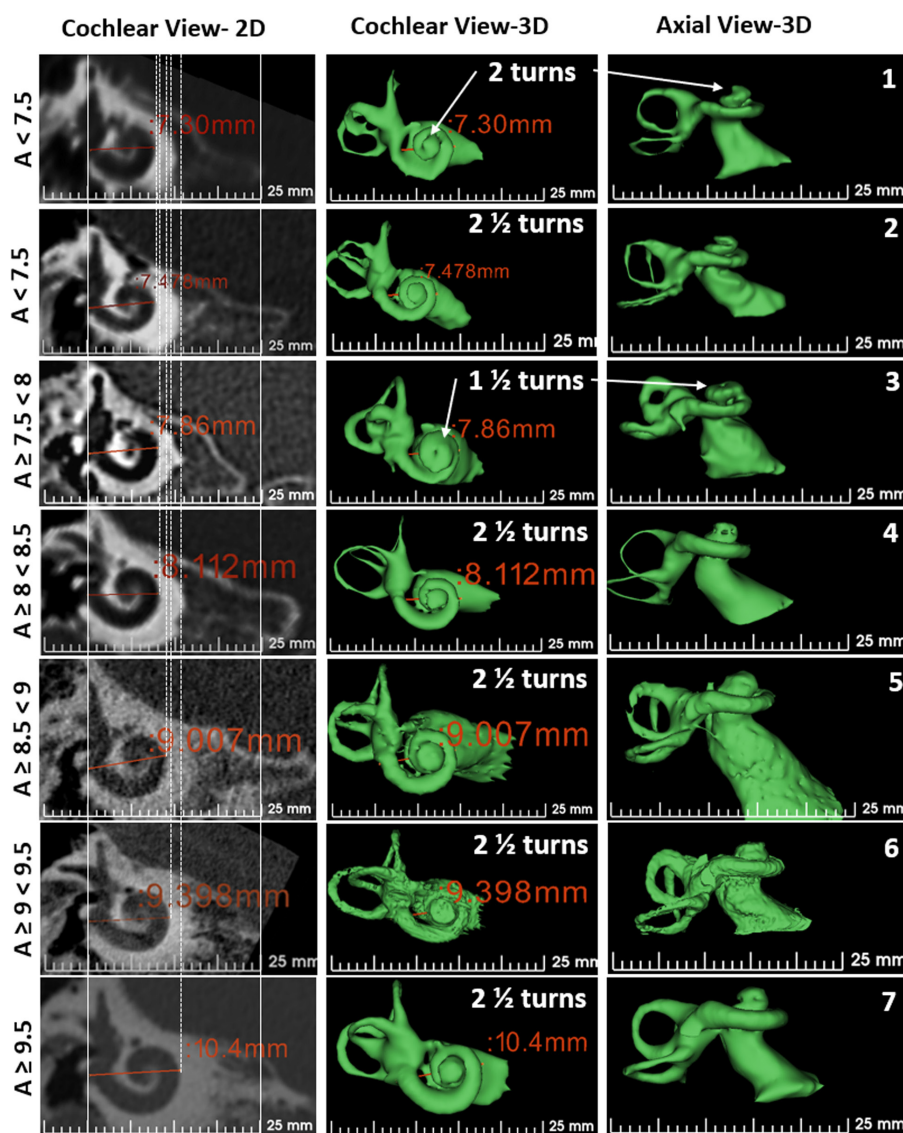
Oblique coronal view of cochlear basal turn as seen in CT scan (column A). Three-dimensional-segmented image of the inner ear in the oblique coronal view (column B) and axial view (column C). The white vertical lines serve as a reference to visualize the variations in cochlear size in the ascending order. CT: computed tomography.
